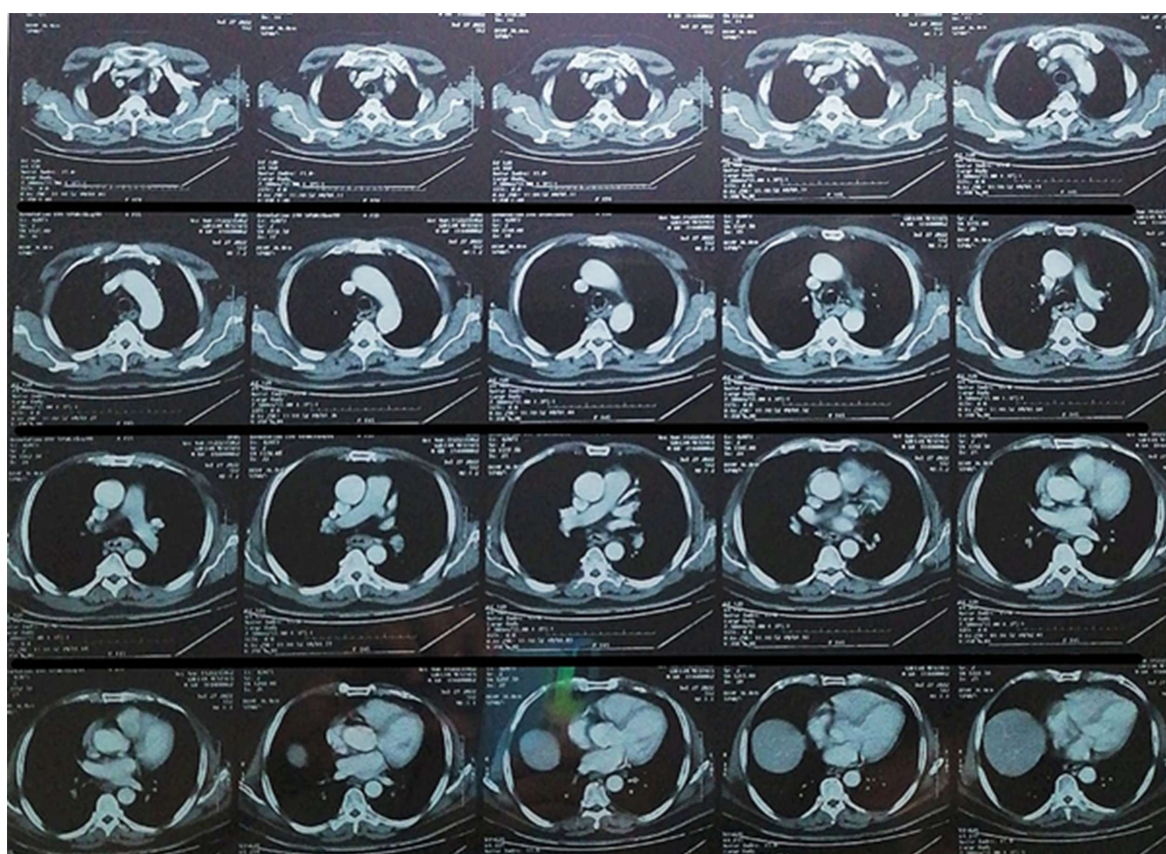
CT scan of leiomyosarcoma
